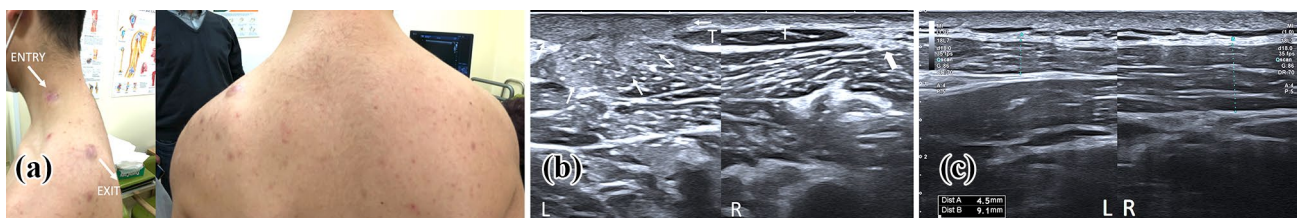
Gunshot wound of the left shoulder (patient #18). A Entry and exit points (white arrows), amyotrophy of the left trapezius. Axonotmesis of the accessory nerve in electroneuromyography. B Comparative axial ultrasound sections showing extensive fibrosis (small white
